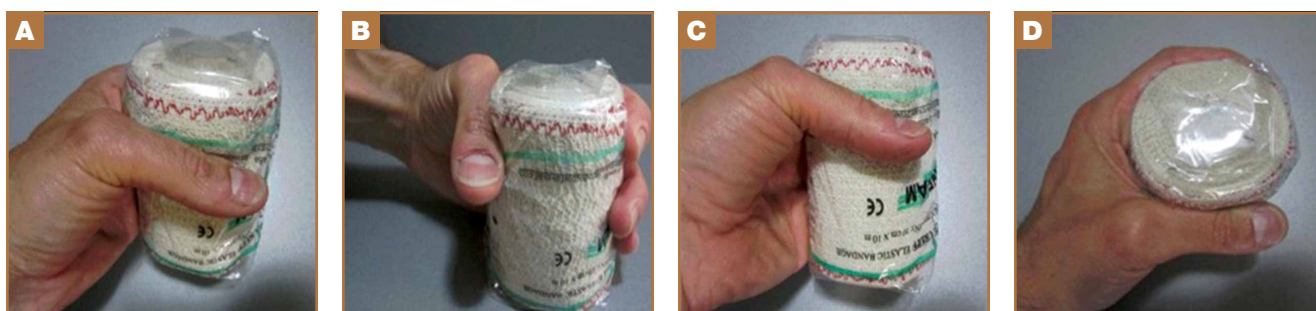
J.J.'s thumb radiographic projection. Accurate thumb positions for performing functional radiographic projection in forced valgus. (A) Lateral oblique view, (B) frontal view, (C) lateral view, and (D) coronal view of position in flexion of metacarpophalangeal joint of thumb.
